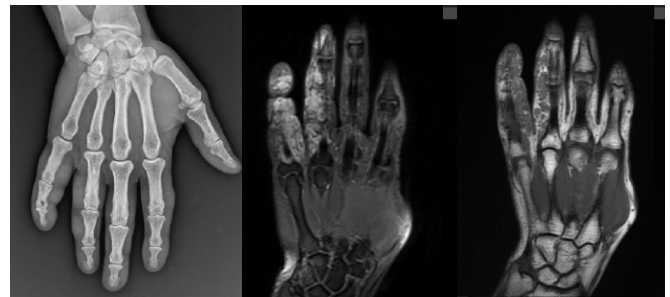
Right hand finger anteroposterior hand radiographs and MRI
